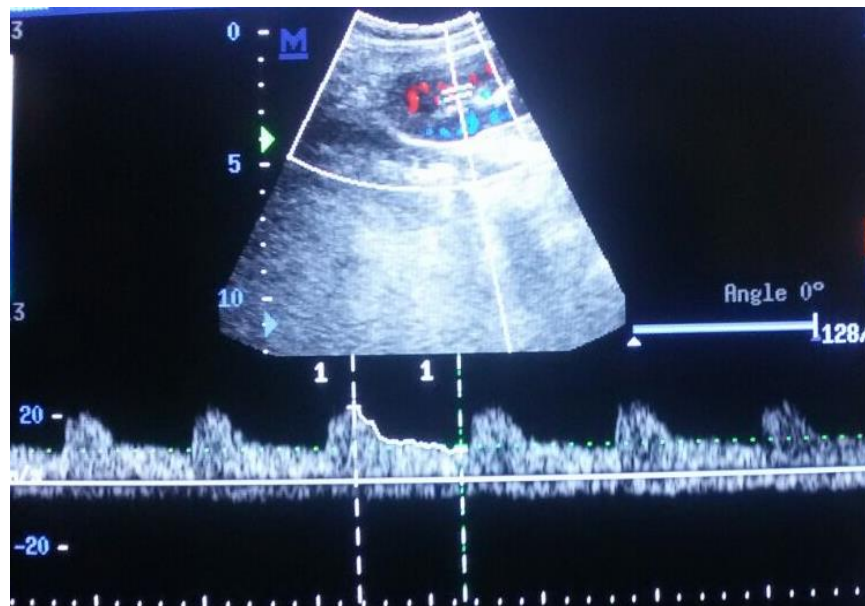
Normal resistive index. A sonogram of a 17-year-old male shows the normal RI for renal transplant. Color Doppler sonogram is used to identify interlobar artery (arrow); waveform is maximized using lowest pulse repetition frequency possible.
